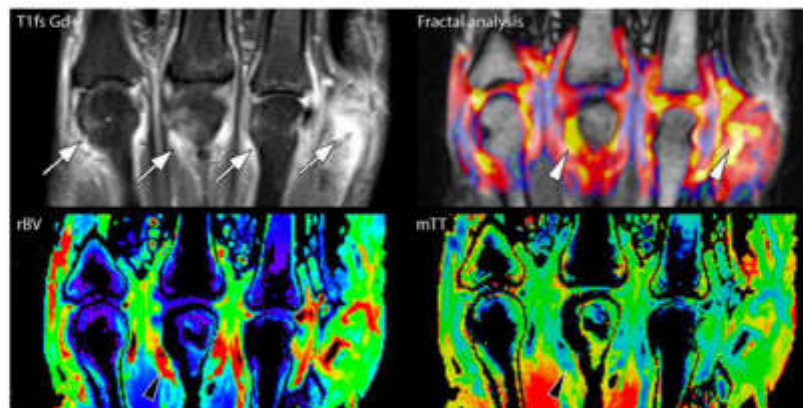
Dynamic contrast-enhanced MR imaging of the hand. A 56-year-old male patient presenting with hand and finger arthritis due to late-onset rheumatoid arthritis. The synovium of all metacarpophalangeal joints is enhanced after contrast administration (arrows). Fractal analysis shows neoangiogenesis in heavily inflamed tissues (white arrowheads). In the perfusion analysis, the relative blood volume is increased while the mean transit time is decreased in synovitis.
